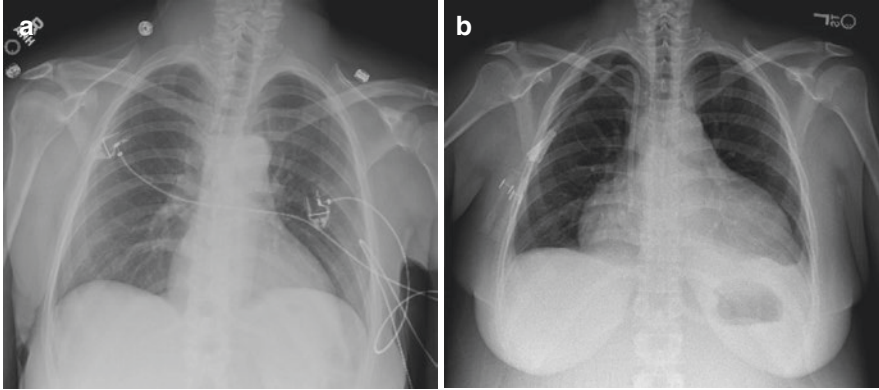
(a) Baseline chest X-ray. (b) Chest X-ray 3 weeks after placement of dialysis catheter; notice the water bottle appearance
